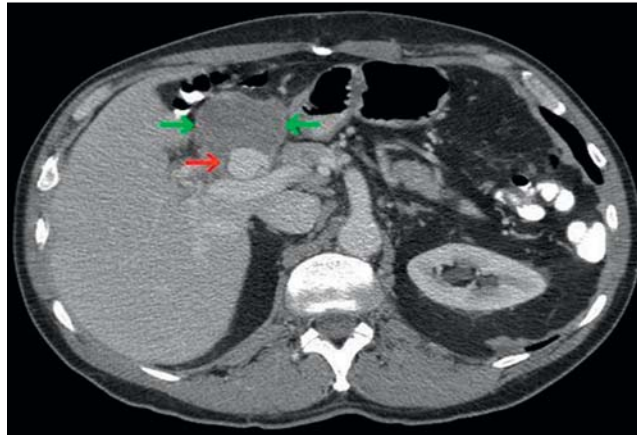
An oral and intravenous contrast-enhanced computed tomography (CT) scan demonstrates a pseudoaneurysm (red arrow) with a surrounding hematoma (green arrows) just above the duodenal bulb and medial to the left lobe of the liver.
